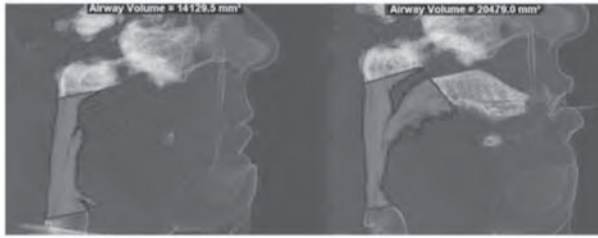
3D i-CAT CT image of a patient's airway before and after MAD placing.
